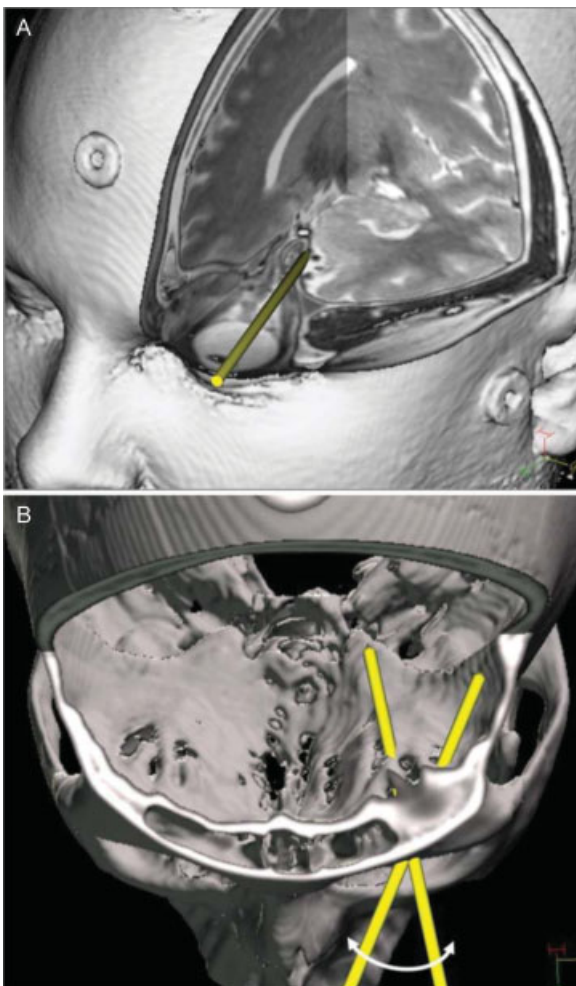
The lid crease incision is one of many small periorbital incisions used in a transorbital neuroendoscopic surgery (TONES) and it may be combined with other periorbital incisions to facilitate better exposure. Pane (A) is a MRI/CT fusion image used in preoperative planning. The wand represents a 4 mm endoscope drawn to scale and inserted through a lid crease incision. In pane (B), also an MRI/CT fusion image, the area bound between the two wands approximates the ipsilateral skull base accessible through a superior lid crease incision. (Adapted from Moe et al⁷⁶ and reproduced with permission from Wiley and Sons.)
